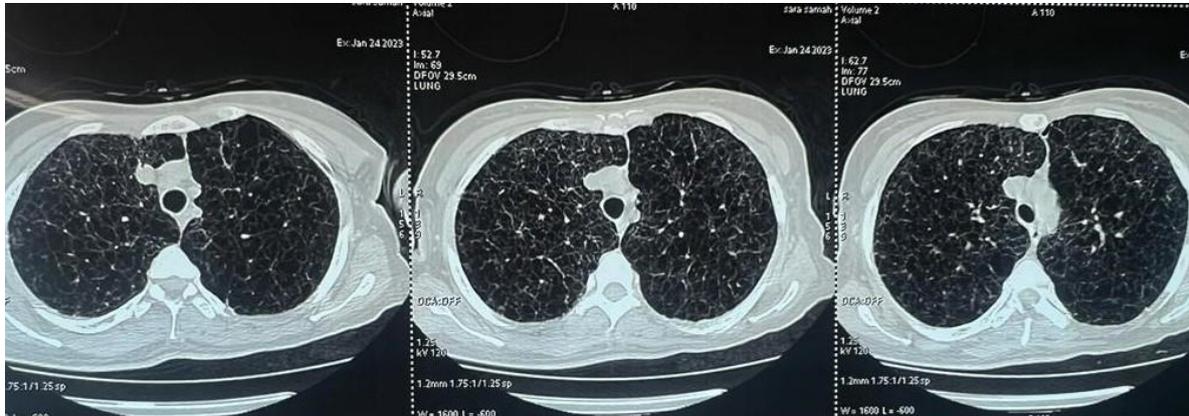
Chest CT scans: showing multiple cystic formations extended to both pulmonary fields
